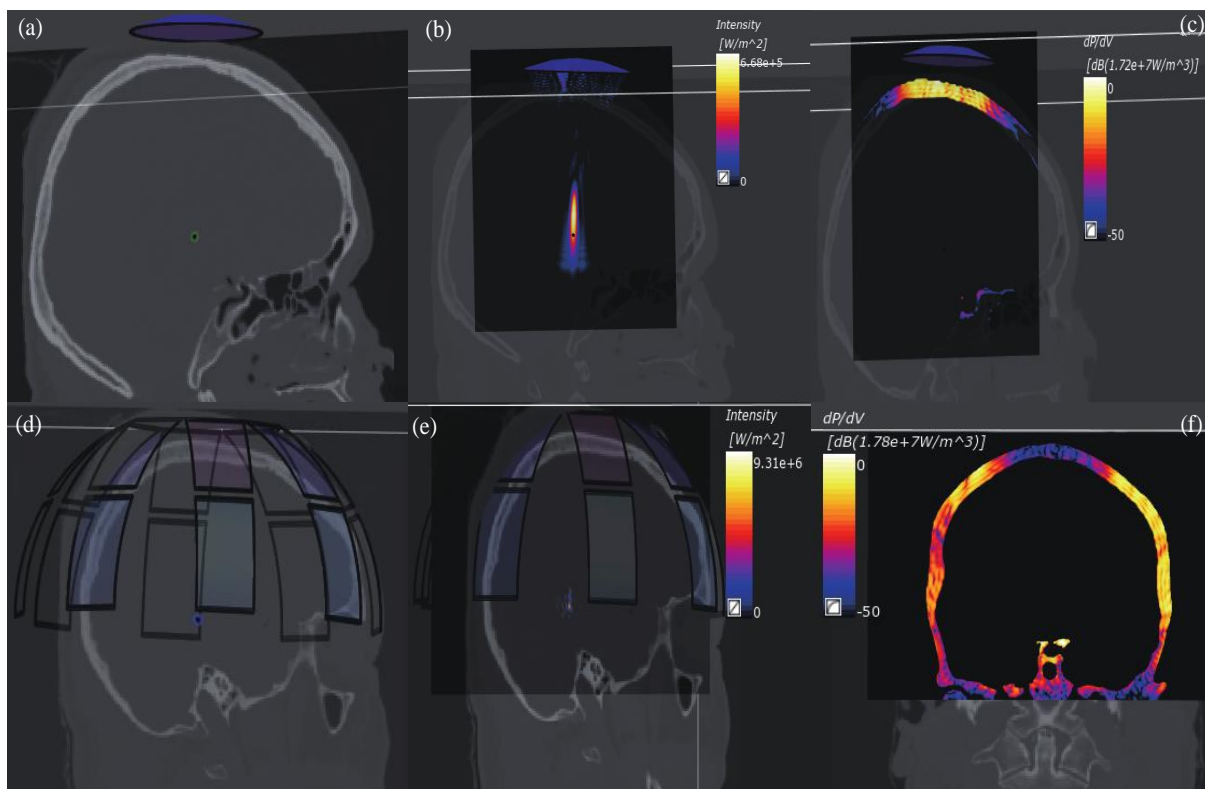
Results of ultrasound propagation within skull, (a) Skull model with SEFT. (b) Intensity distribution when acoustic waves of SEFT propagate through the skull. (c) Energy
